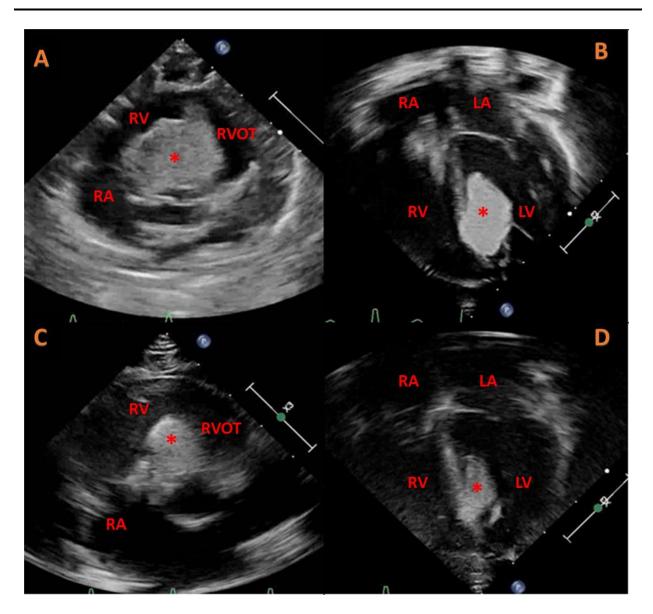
Postnatal transthoracic echocardiogram in the same patient. A-B: Regrowth of cardiac rhabdomyomas at 59 days of life while off sirolimus. A. Parasternal short axis showing the right ventricular rhabdomyoma. B. Apical 4 chamber showing the left ventricular rhabdomyoma. C-D: Transthoracic echocardiogram images at approximately 3 months of age after 2 weeks of sirolimus therapy showing a decrease in size of both rhabdomyomas. C. Parasternal short axis showing the right ventricular rhabdomyoma. D. Apical 4 chamber showing the left ventricular rhabdomyoma. (RA: right atrium; RV: right ventricle; LV: left ventricle; LA: left atrium; RVOT: right ventricle outflow tract; *: rhabdomyoma).
